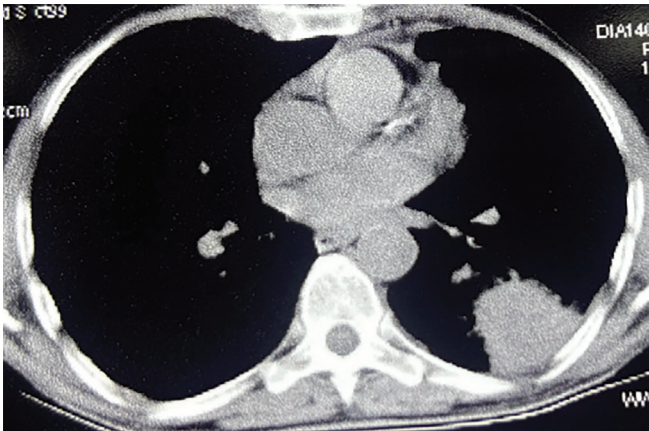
Computed tomography thorax showing pleural-based lung mass in left lower lobe
